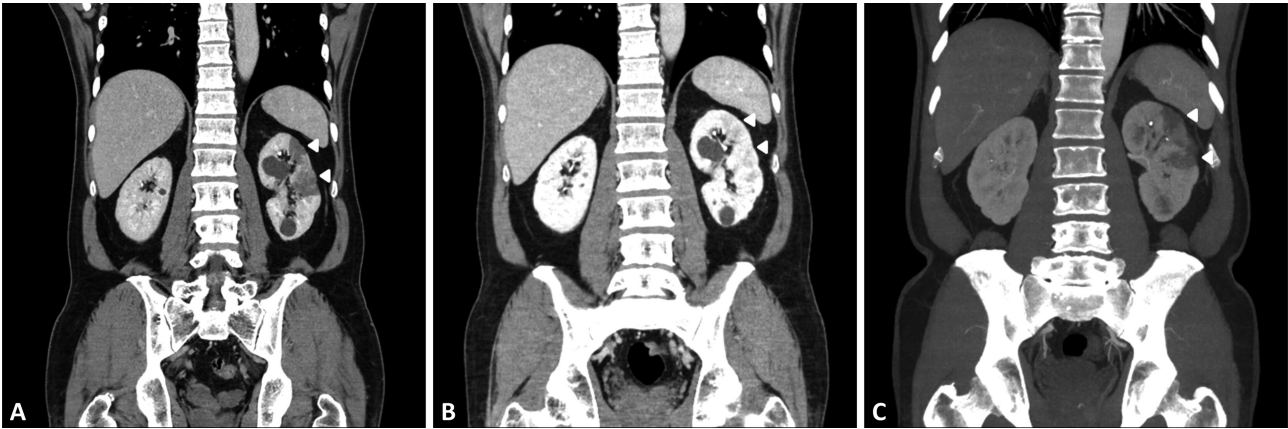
Serial coronal views of abdominal CT scans of the patient with renal infarction. (A) An abdominal CT scan at the local hospital showed a perfusion defect in the left kidney (arrowhead); (B) The perfusion defect spontaneously resolved (arrowhead) in our emergency room; (C) The perfusion defect recurred (arrowhead) on the sixth day of hospitalization.
